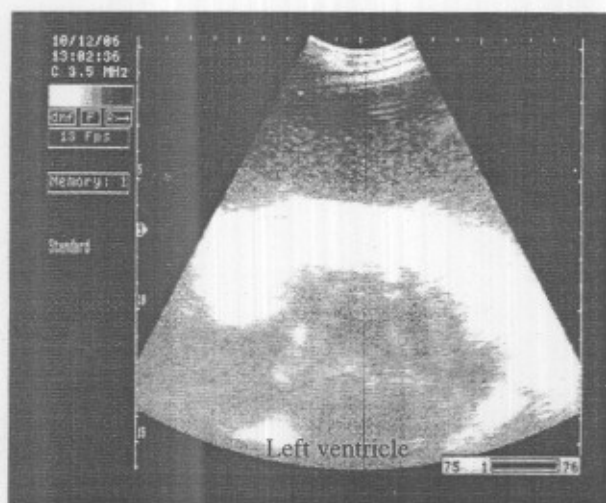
Ultrasonographic image shows presence of hypoechoic fluid (pus) a. or echogenic network (fibrin) b. in pericardial sac in between the two layers of pericardium (imaged from 3rd intercostals space of left thorax). Using 3.5 MHz sector probe.
